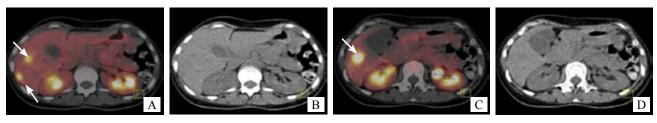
Transverse fused PET/CT images of the upper abdomen (A, C), showing three sites of abnormal 18F-FDG accumulation in the hepatic parenchyma (SUVmax: 10.3). These foci are actually not detected by the low dose localizing CT (B, D).
